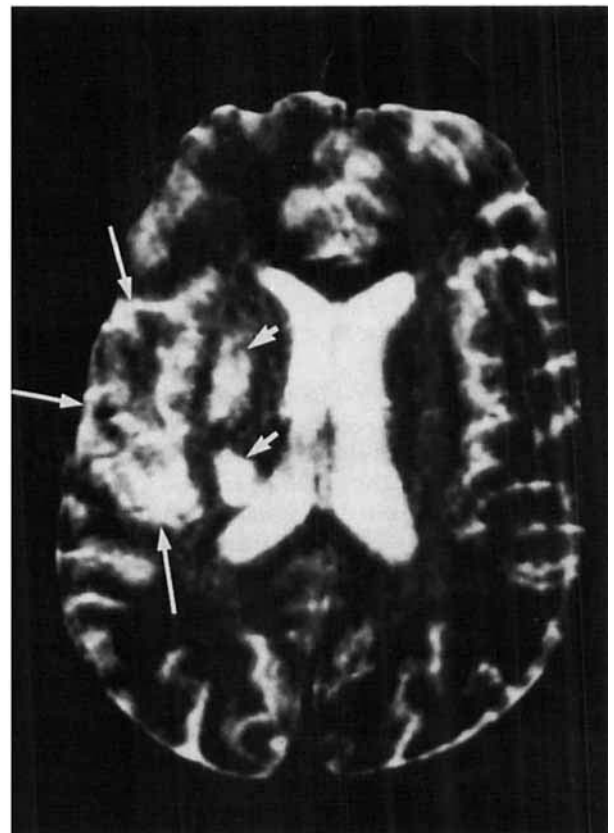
Although movement artifacts make definitive interpretation impossible, a T2-weighted head magnetic resonance imaging scan of Subject 3 shows a distinct large area of hyperintensity in the right inferoposterior temporal region (long arrows) and two deep-seated lesions in the region of the lentiform nucleus (short arrow) and posterior white matter (short arrow).
